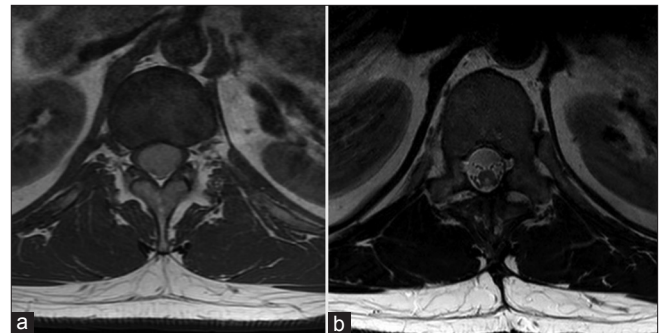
(a) and (b) Axial T1-weighted MRI with gadolinium contrast demonstrating diffuse enhancement with severe canal compromise (left). Axial T2-weighted MRI at one year demonstrating tumor excision (right)
